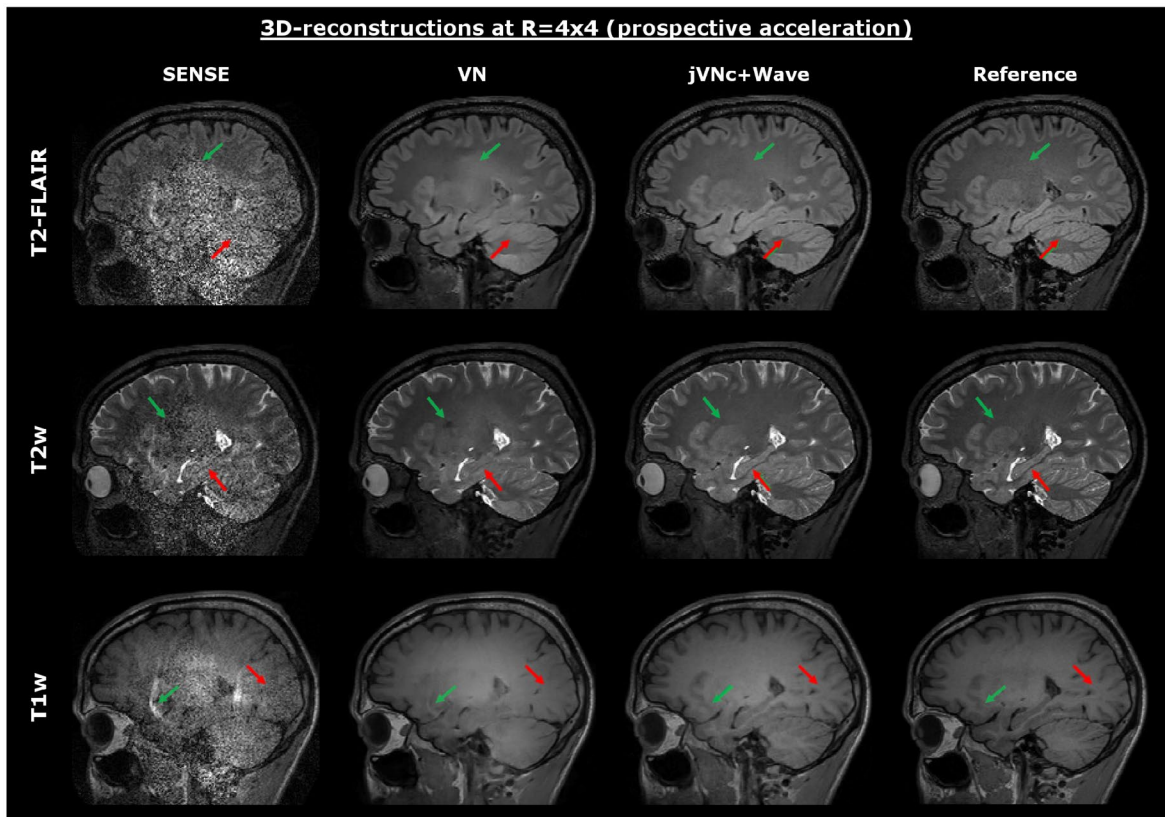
The variational networks were tested on prospectively accelerated data acquired at $R = 4 \times 4$ acceleration (combined TA = 2:53 min). The sequence specific contrast was retained in all scans, but *jVNc + Wave* better preserved fine anatomical details (red arrows) and exhibits fewer artifacts (green arrows) than *VN*. Nevertheless, at such high acceleration ($R = 16$) also the *jVNc + Wave* reconstructions resulted in small image blurring, for example in the cerebellum of T2-FLAIR
